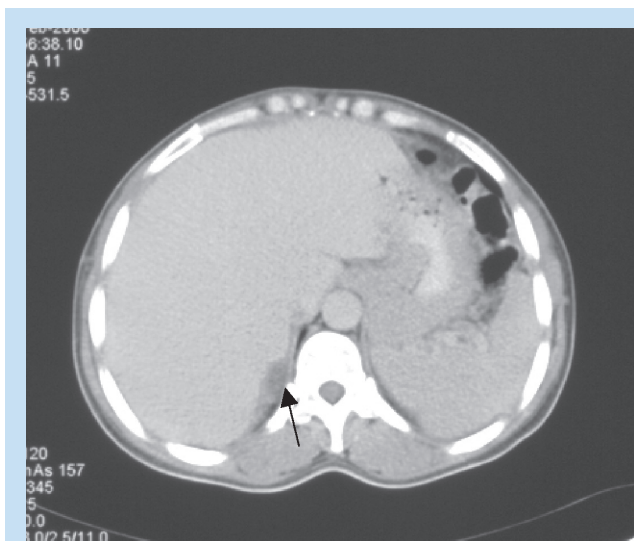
Axial venous phase CT demonstrates a low-density area in the region of the right adrenal gland suggestive of a possible mass.
